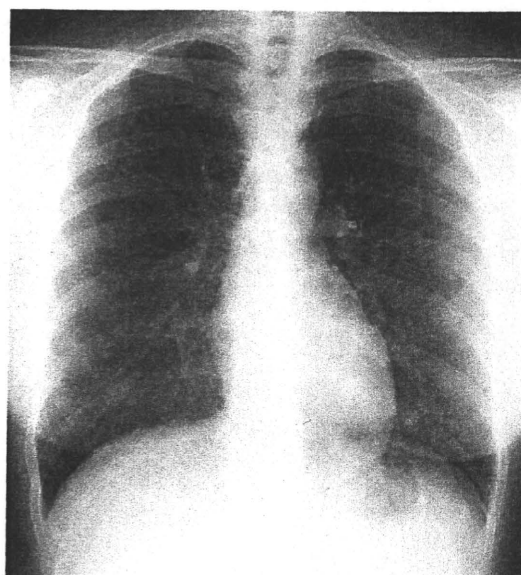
Chest radiograph on first visit showed multiple bilateral pulmonary nodules.
